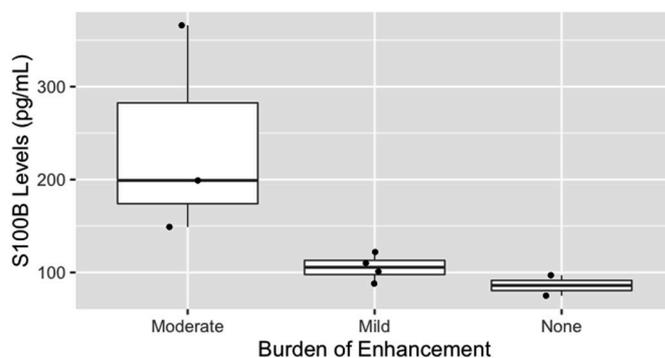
S100B levels by extent of enhancement on MRI
